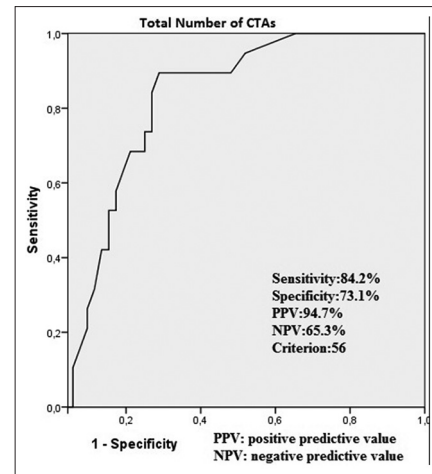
The curve demonstrating the optimal comet tail artifact cut-off value for forced vital capacity in diagnosis of patients with ultrasonographic-spirometric interstitial lung disease (Interstitium was accepted as affected in case that forced vital capacity % value was 80 or below 80)
